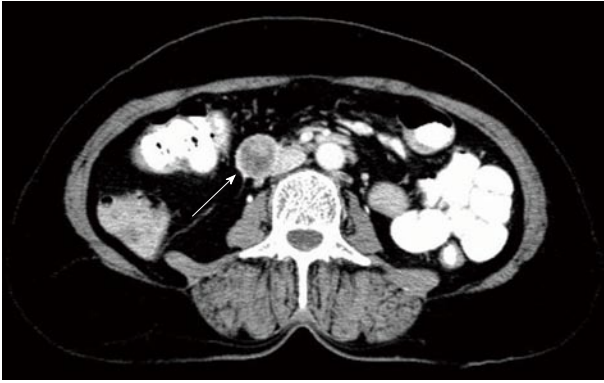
Computed tomography showed a well-demarcated enhancing tumor 4.0 cm in diameter in the third portion of the duodenum (white arrow).
